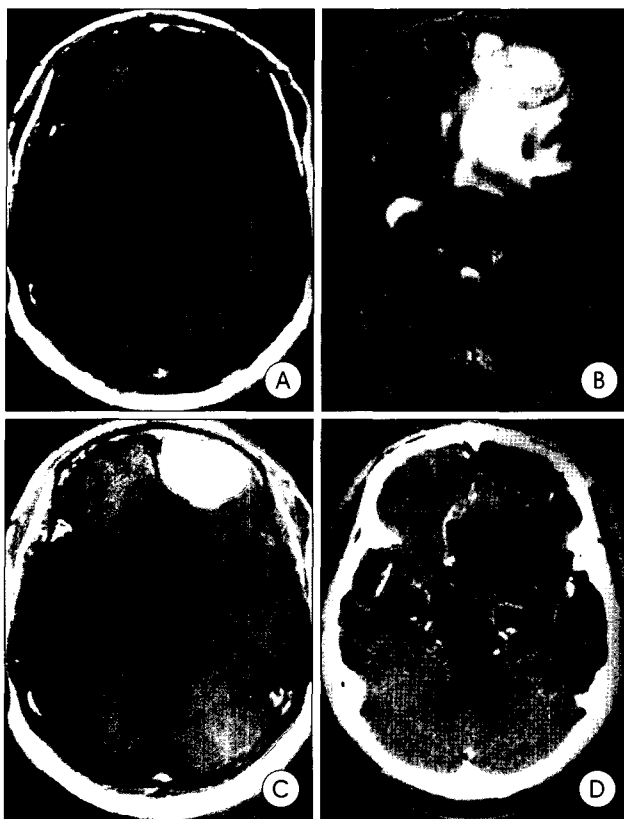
Magnetic resonance imaging showing a large (3.5×3.0cm sized) homogeneously contrast enhancing mass which filled the left frontal lobe. The mass is attached to the left frontal convexity and a dural tail, enormous peritumoral edema and midline shift are observed (A~C). Elective left frontal craniotomy is performed and a total excision of the mass and the originating dura mater (Simpson grade I) was done (D).
